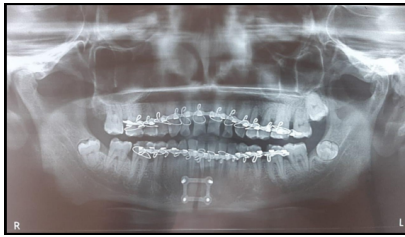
Post-operative orthopantomogram revealing position of 3D plate
